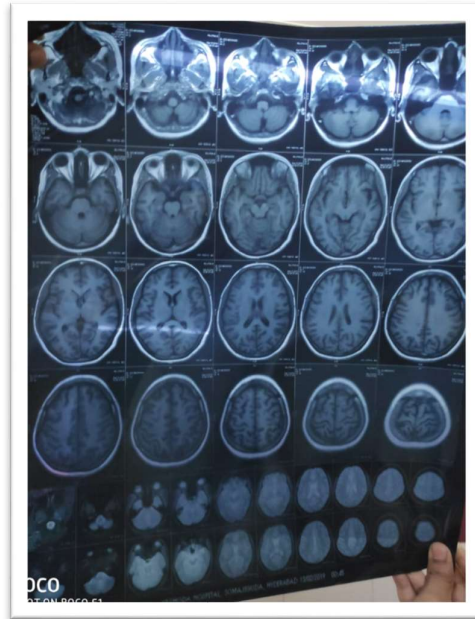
MRI brain & spinal cord S/O demyelinating lesions in periventricular white matter and adjacent optic chiasma
